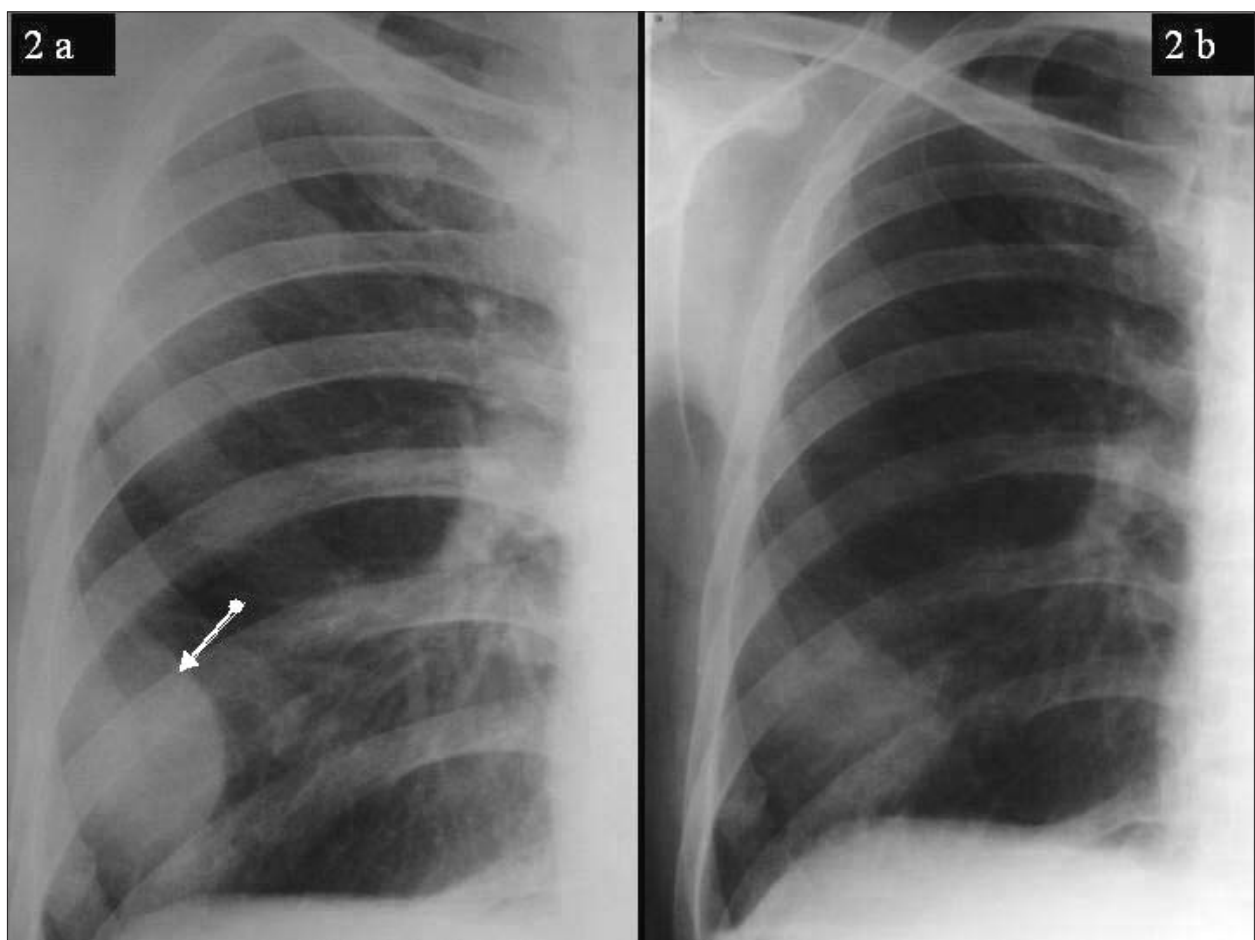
a, b. - Patient 4. (a) Postero-anterior chest roentgenogram revealing an opacity of 5x3 cm in the lower chest with a sharply defined convex contour facing the lung (arrow) with tapered superior and inferior margins together with a fracture of the 7th rib. (b) Chest roentgenogram showing spontaneous resolution after 4 days.
